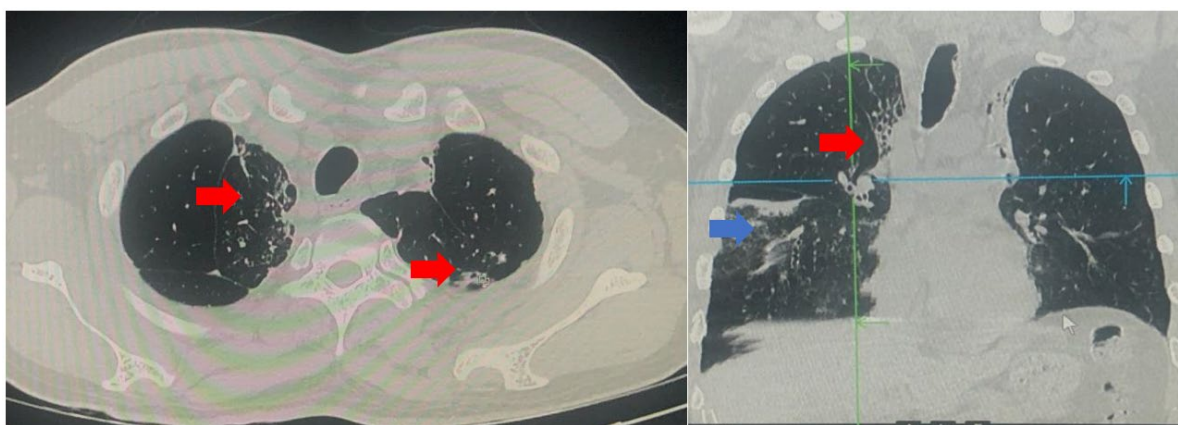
High-resolution Chest Computed Tomography Scan showing bronchiectatic changes on both upper lobes (red arrow), as well as a right lobe ground glass opacities (blue arrow) consistent with pneumonia
